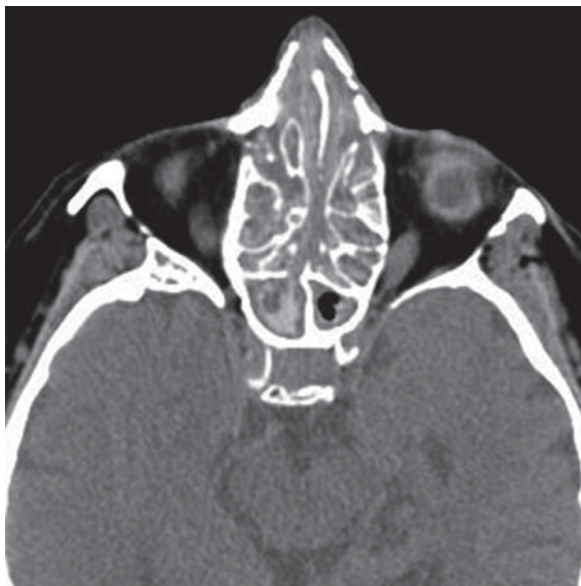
Allergic fungal sinusitis. Axial CT shows the nasal cavity and ethmoid air cells to be filled with hyperdense secretions between layers of thickened, hypodense mucosa
